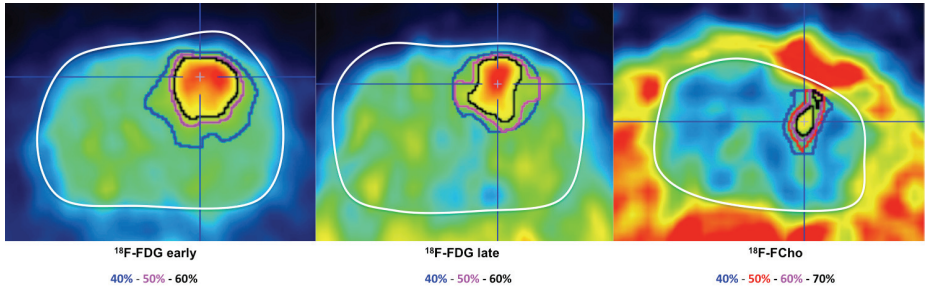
Selection of the threshold for defining the metabolic tumor volume (MTV) on conventional ^{18}F -FDG PET (left), delayed ^{18}F -FDG PET (center) and ^{18}F -FCho PET (right). For clarity, the whole brain is contoured in white. For both ^{18}F -FDG PET (both 40-60 min post-injection and 240 min post-injection) a threshold contouring $\geq 60\%$ of the maximum uptake is selected (black VOI). For ^{18}F -FCho PET, a threshold contouring $\geq 50\%$ of the maximum uptake is selected (red VOI).
